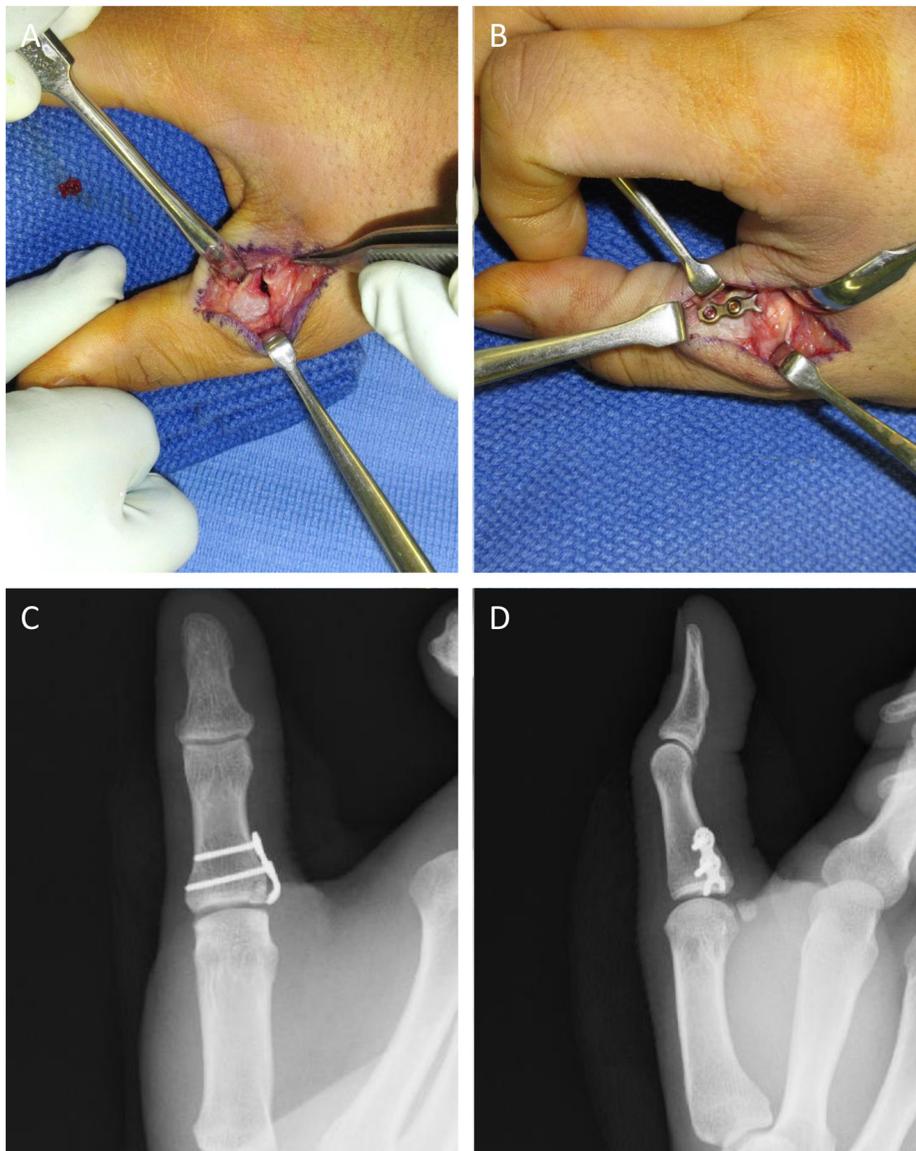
A. Intraoperative image of Case 2 before reduction. B. Intraoperative image of Case 2 after hook plate fixation. C and D. Postoperative radiographs demonstrate anatomical reduction of the bone fragment.
